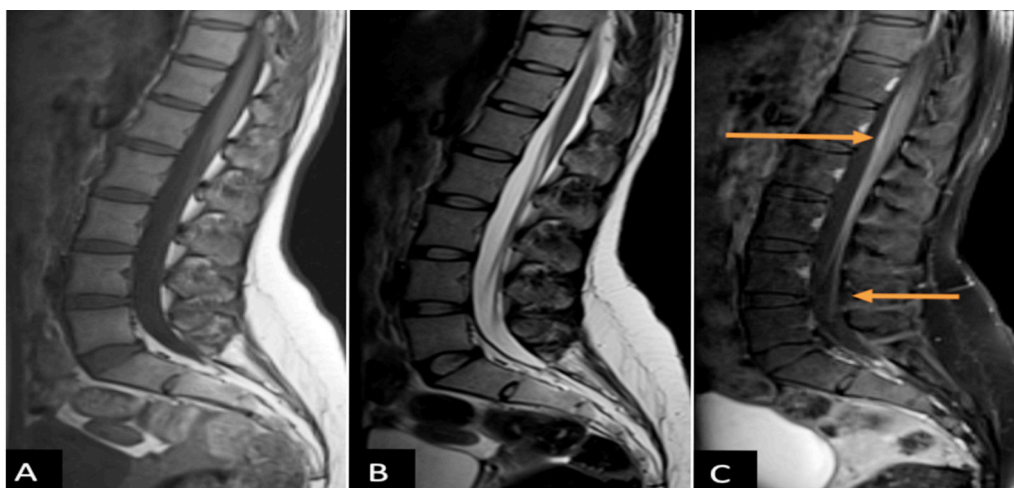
Arachnoiditis. Sagittal MRI images of the lumbar spine, T1w (A), T2w (B), Post-contrast (C) show thickening and enhancement of the thecal sac and the Cauda equina nerve roots (arrow).
